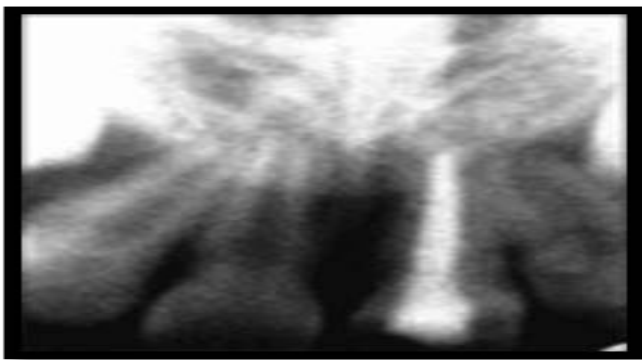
Radiograph showing complete obturation
